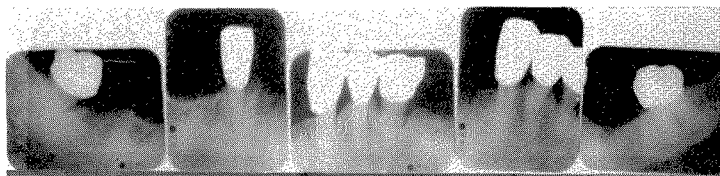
Roentgenograms taken in March, 1958.
